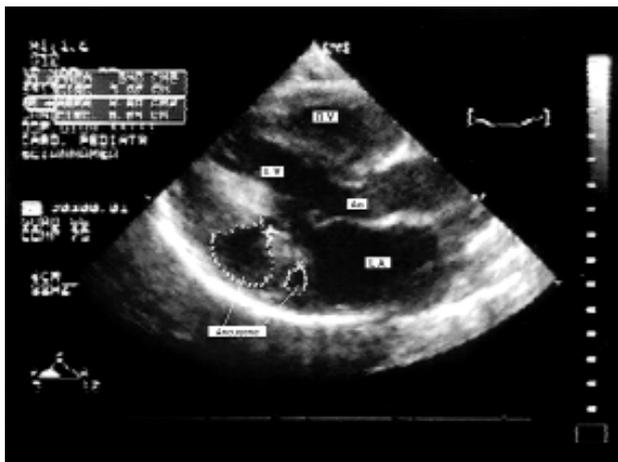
Transthoracic echocardiography (parasternal long-axis view): note the two aneurysms of the left ventricle signed by the outline. Ao = aorta; LA = left atrium; LV = left ventricle; RV = right ventricle.
